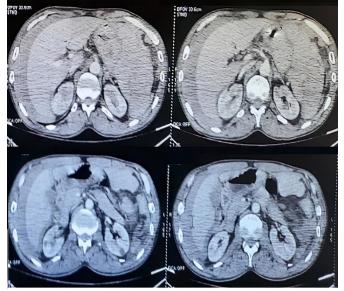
Abdominal CT scan C-C+: a mediumsized hemoperitoneum on probable splenic rupture
